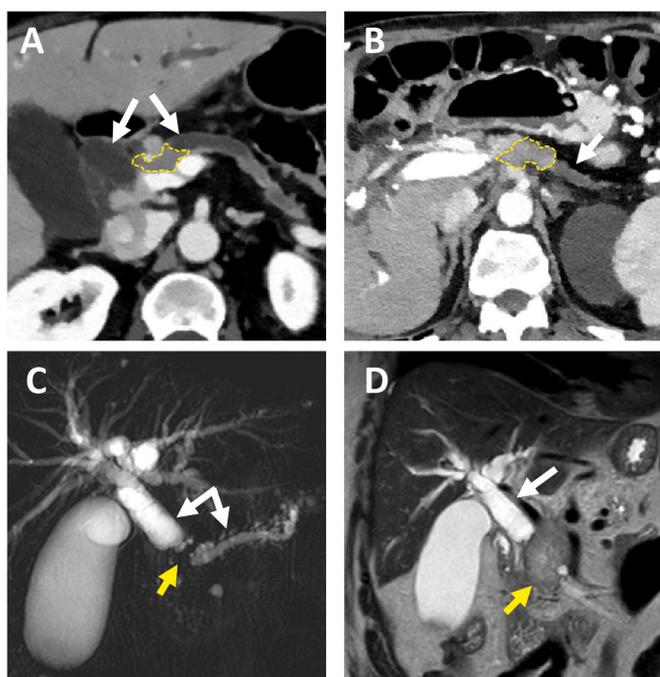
Typical findings of PDAC. (A) depicts a double duct sign, where both the main pancreatic duct and the biliary tree are dilated (arrows) due to an obstructing tumor in the pancreatic head (dashed line). In (B) there is parenchymal atrophy of the pancreatic tail (arrow), due to an obstructing tumor in the pancreatic body (dashed line). (C) shows a double duct sign in MRCP (white arrows), caused by a presumed obstructing lesion (yellow arrow). (D) reveals an obstructing (white arrow) pancreatic head tumor in a T2-weighted image (yellow arrow).
